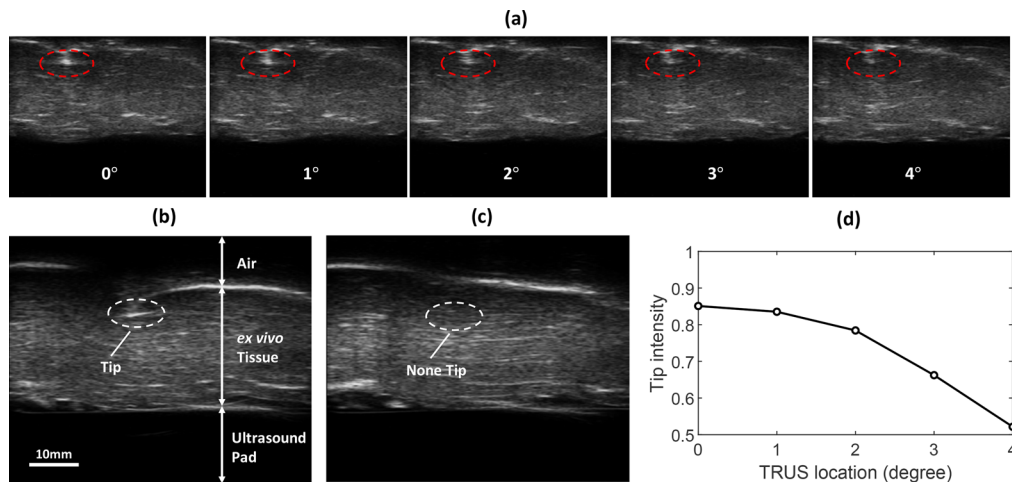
(a) A set of B-mode images with varying tip intensity. The da Vinci surgical instrument tip is within the red dashed circle. The reference location is 0° . (b) The B-mode image at the reference location. It can be partitioned into 3 layers: from top to bottom are air, *ex vivo* tissue and ultrasound pad. (c) The B-mode image at a location transcending the sensitive range. (d) The tip intensity versus TRUS location. As the TRUS location moves away from the reference location 0° , the corresponding tip intensity keeps reducing.
